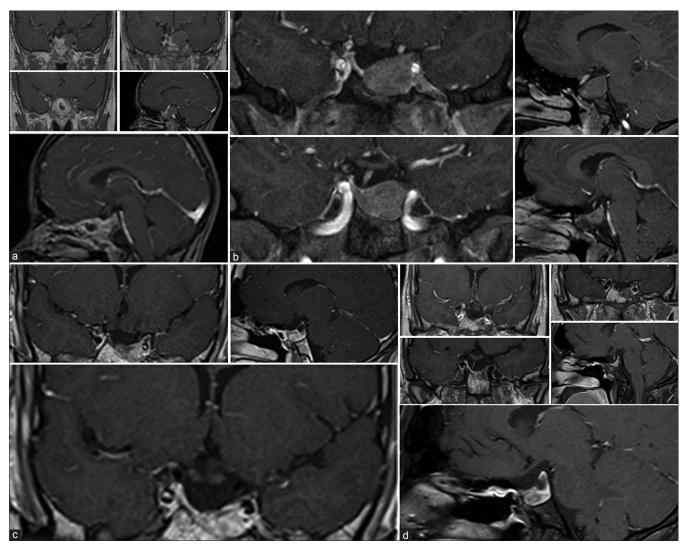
MR imaging. (a) Pre-operative from 5/1999. (b) Recurrent adenoma, 2008. (c) MRI s/p endoscopic endonasal approach (2nd operation), 2009. (d) Recent MRI, 12/2012
